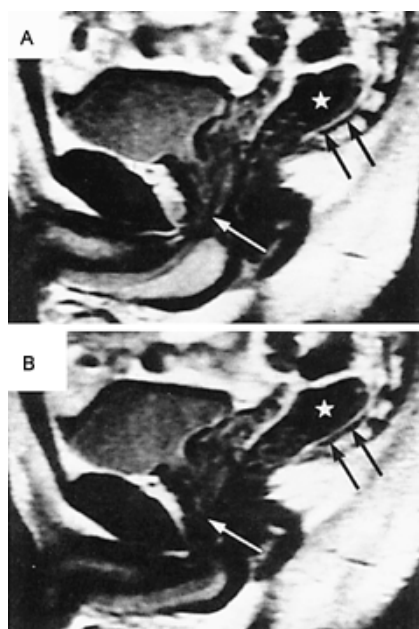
4. Sagittal magnetic resonance images of the male pelvis taken at rest (A) and during contraction of the pelvic floor muscles (B). These functional magnetic resonance images show that with contraction of the pelvic floor there is an elevation of the prostate and bladder base such that the membranous urethra is elongated (an average of 0.5 cm) and the retropubic space narrows. (From Mikuma N, Tamagawa M, Morita K, et al. *Magnetic resonance imaging of the male pelvic floor: the anatomical configuration and dynamic movement in healthy men. Neurourol Urodyn 1998;17:591*, with permission.)
